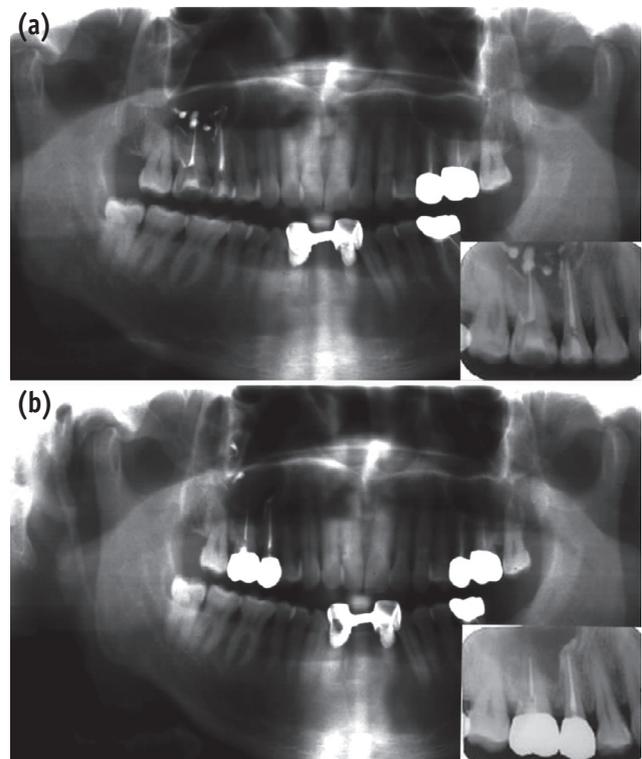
(a) Panorama radiographs and standard radiographs (inlet square) after temporary root canal dressing material using Calcipect II, which was spilled into the periapical area; (b) Panorama and standard radiographs (inlet square) in one and half year. Some Calcipect II granules were gradually migrated into maxillary sinus through the mucoperiosteal space, although their radiopacity was reduced.
